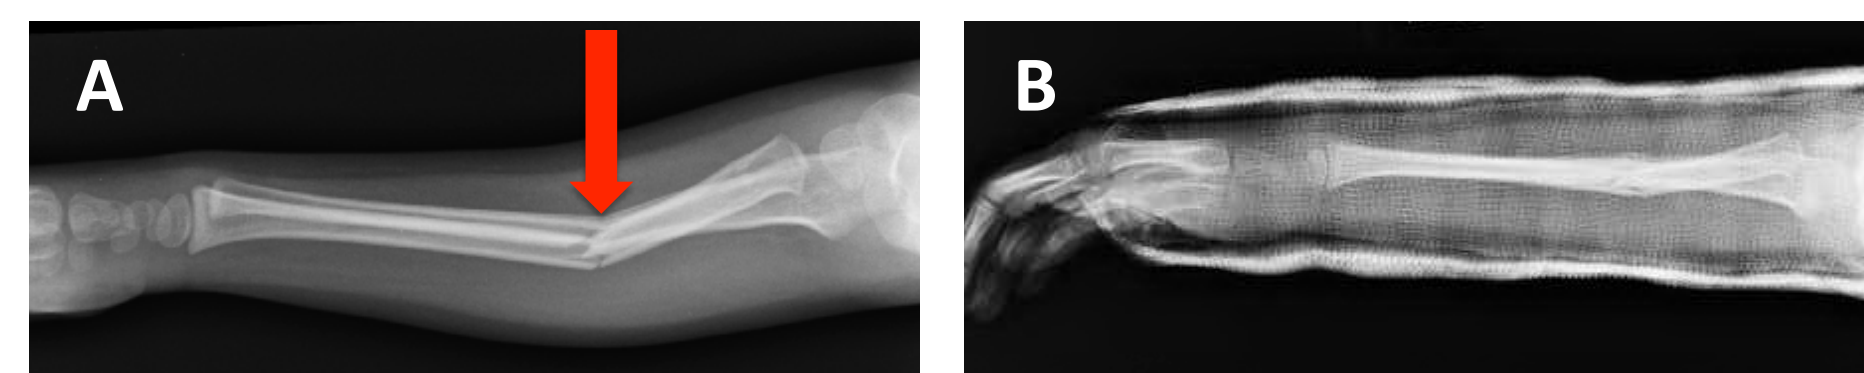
A. X-ray of green stick fracture. B. X-ray of properly reduced green stick fracture [1]
